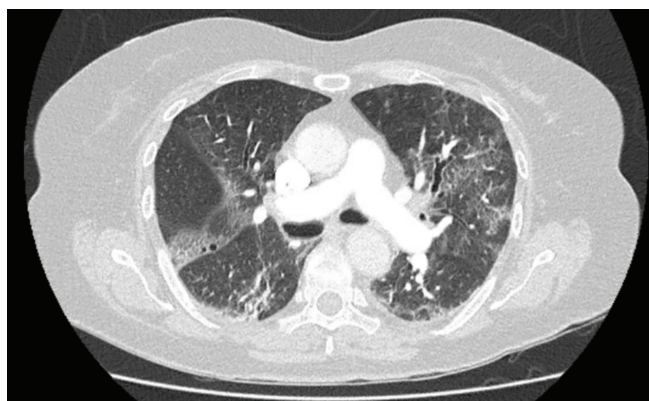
Chest CT scan with multiple, bilateral, frosted glass ranges with fibrosis
